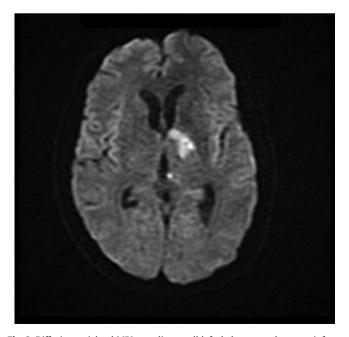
Diffusion weighted MRI revealing small left thalamocapsular acute infarct.
